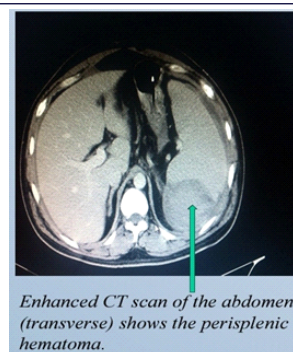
Enhanced CT scan of the abdomen v(transverse) shows the perisplenic hematoma.
